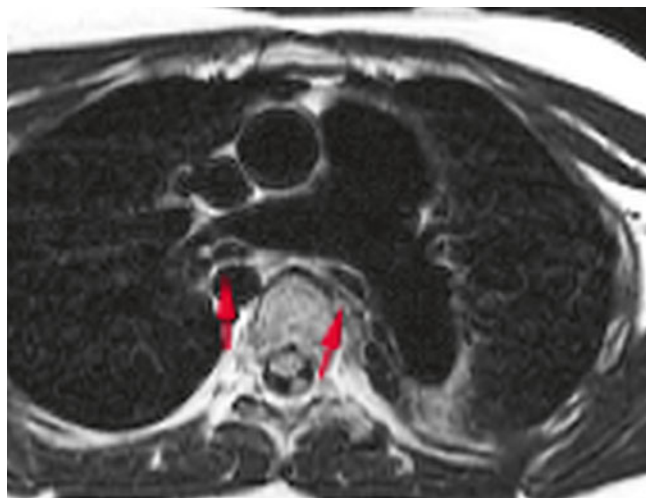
Black blood axial magnetic resonance image in a patient with Tetralogy of Fallot with absent pulmonary valve syndrome. Note the dilated right and left pulmonary arteries with compression of the right and left mainstem bronchi (arrows) (Courtesy of Cynthia Rigsby MD, Department of Medical Imaging, Children's Memorial Hospital, Chicago, Illinois)
